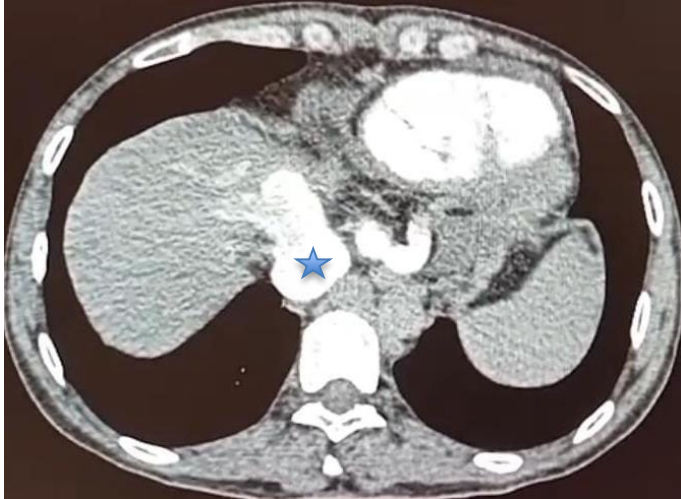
Axial CT image showing dilated IVC stump (★) with enlarged hepatic and azygos veins.
